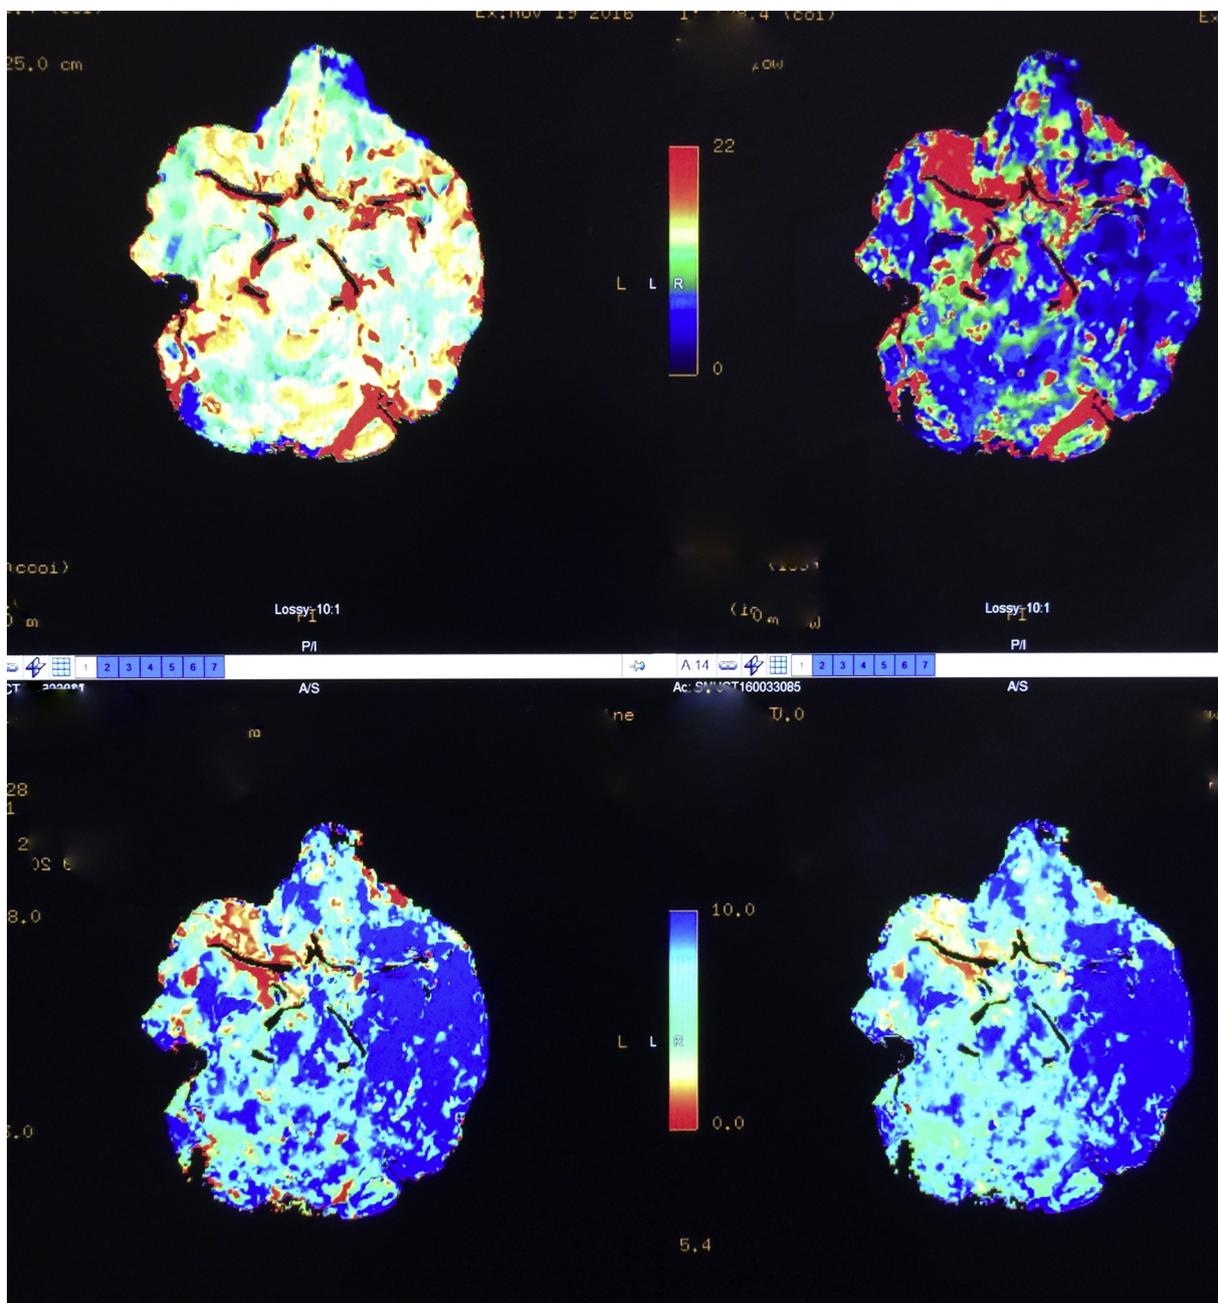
CT Perfusion demonstrating left MCA territory salvageable ischemic penumbra
